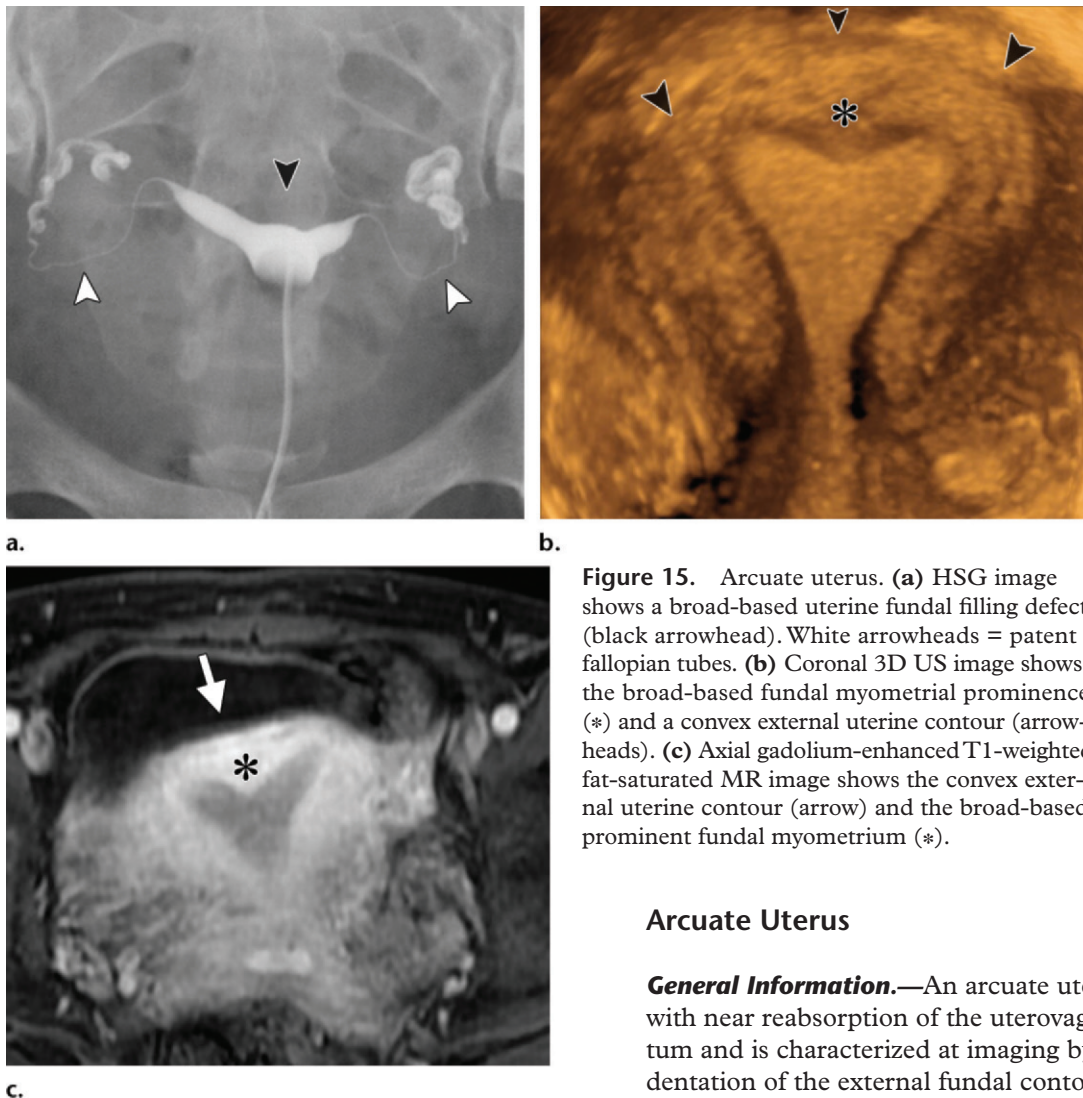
Arcuate uterus. (a) HSG image shows a broad-based uterine fundal filling defect (black arrowhead). White arrowheads = patent fallopian tubes. (b) Coronal 3D US image shows the broad-based fundal myometrial prominence (*) and a convex external uterine contour (arrowheads). (c) Axial gadolinium-enhanced T1-weighted fat-saturated MR image shows the convex external uterine contour (arrow) and the broad-based prominent fundal myometrium (*).
